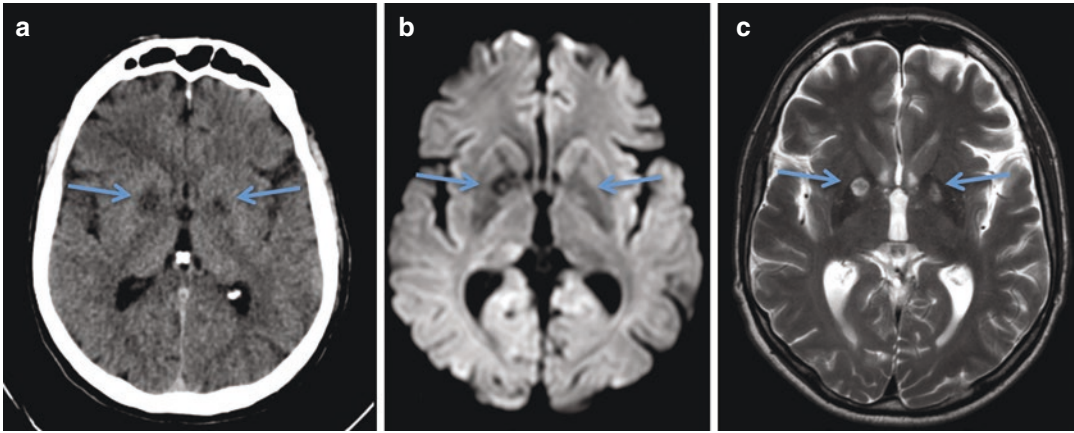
Carbon monoxide poisoning in a 53-year-old man attempting suicide. CT (a) and MRI (b: DWI, C: T2-w TSE) show selective involvement of the globi pallidi with the right side more severely injured (a–c: arrows)
